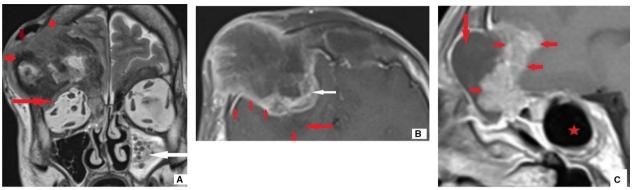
T2-flair coronal MRI (A) shows the large right frontal sinus tumour with extension into subcutaneous tissues (small arrows) and intraorbital extension (long red arrow), invading right anterior ethmoid air cells. The left maxillary sinus shows opacification with fluid and bubbly secretions. Fig. B (post-contrast axial) and C: (post-contrast sagittal) MR image shows solid tumour invading the dura and brain parenchyma with focal brain oedema (long red arrow; b)
